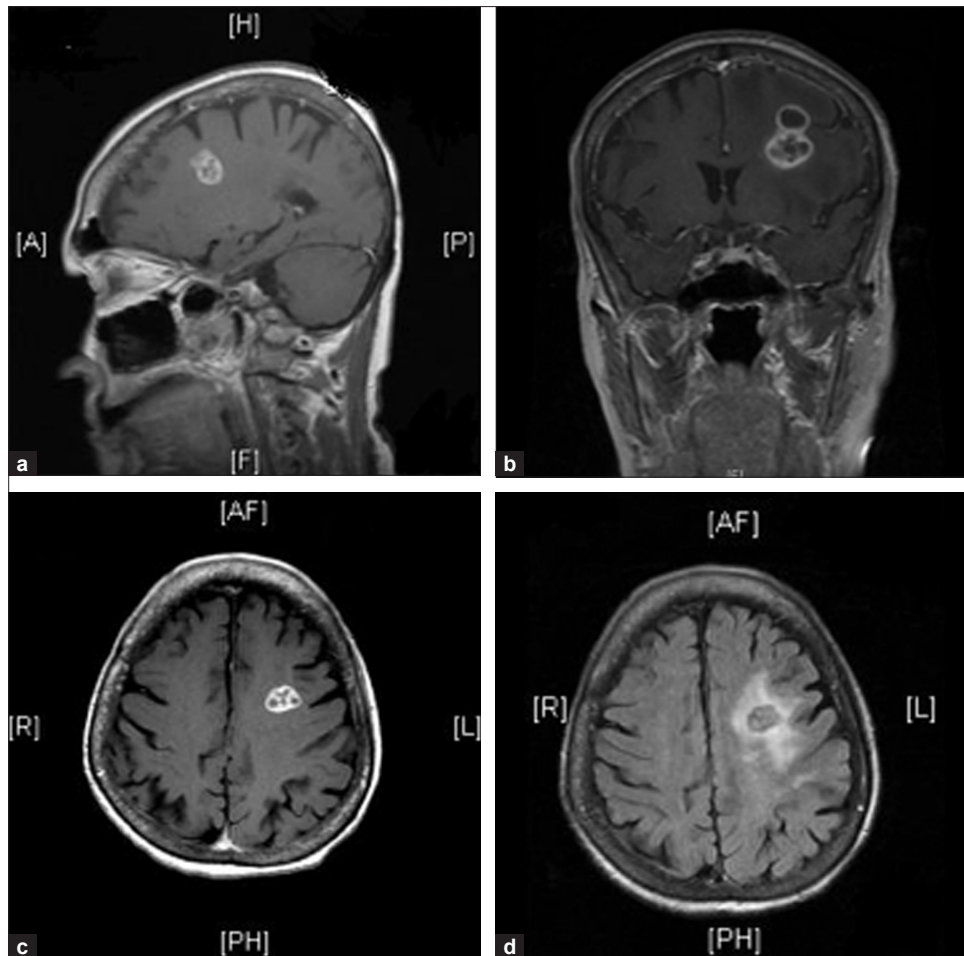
Sagittal and coronal T1 post-contrast MRI scans demonstrating a decrease in size of the ring enhancing lesion located deep in the left frontal lobe with decrease in surrounding edema (see FLAIR image right lower panel)
